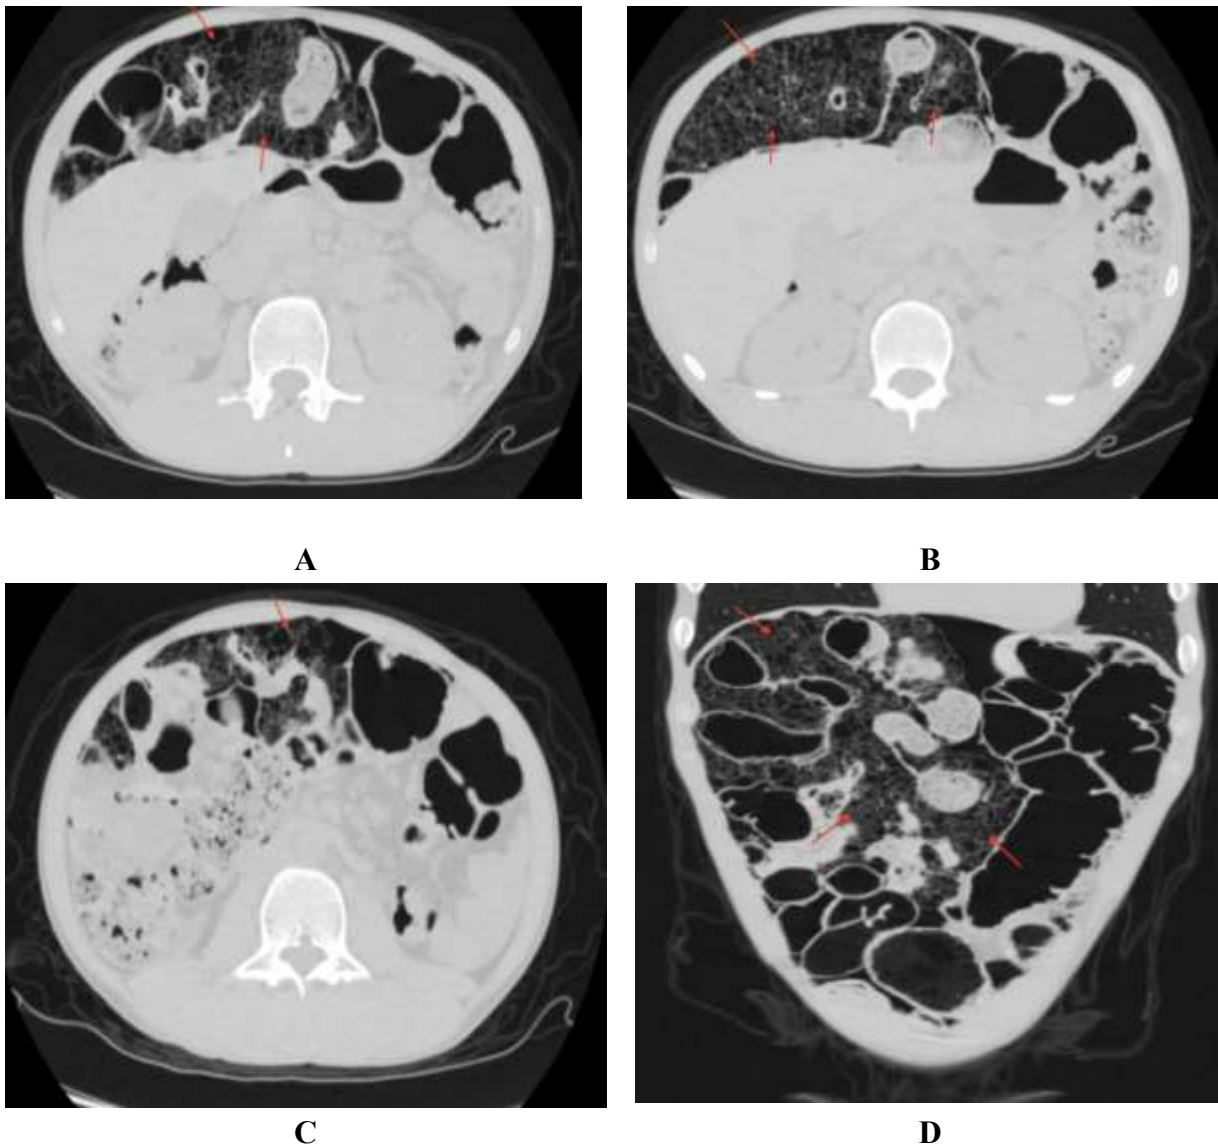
CT images demonstrating pneumatosis cystoides intestinalis.
